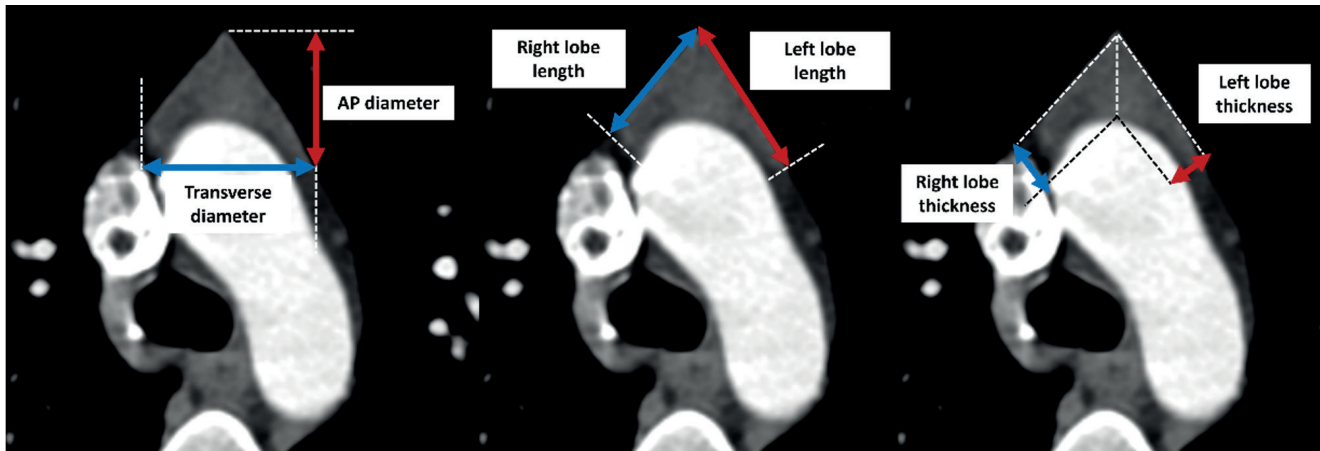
Measurements of thymic diameters on CT
